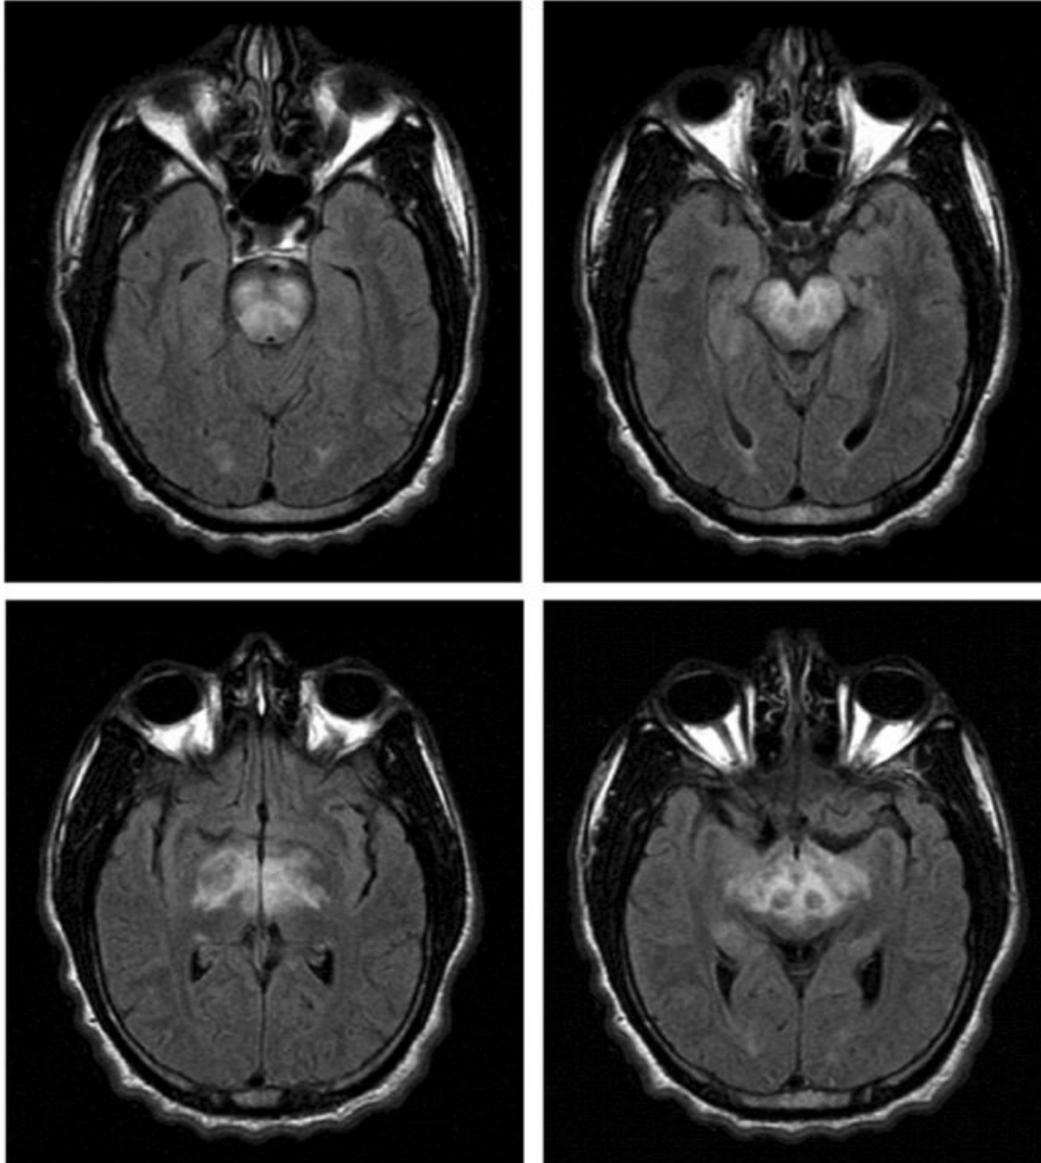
(above): This MRI brain scan shows hyperintensities in the brainstem, as witnessed by the areas with increased brightness.
